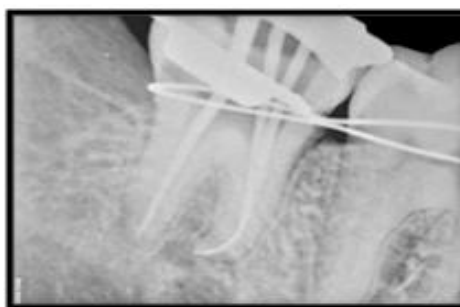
(b): Master cone radiograph
